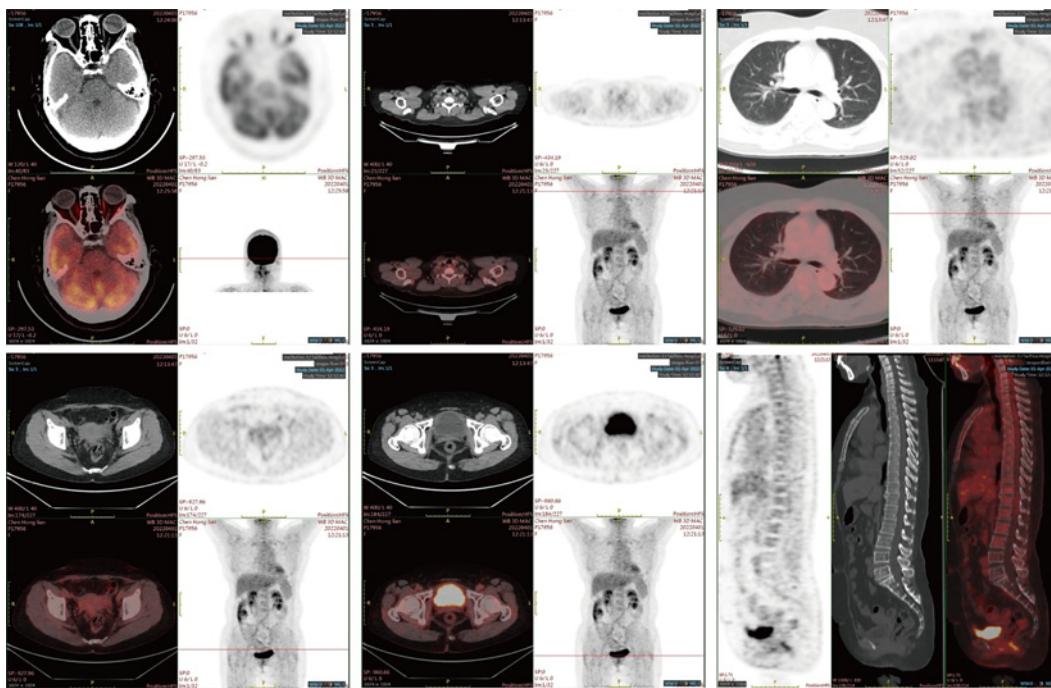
PET-CT after the excisions of eyelid mass.
